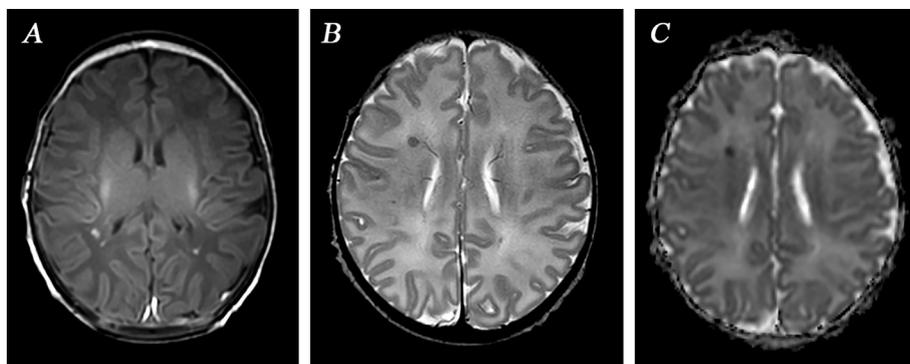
Posterior predominant PWMLs in a term infant with Tuberous Sclerosis. Axial MRI, performed on day 8. Several punctate lesions are seen as increased signal on T1 (a), one in the right frontal lobe as decreased signal on T2 (b) as well as on the ADC map (c).
